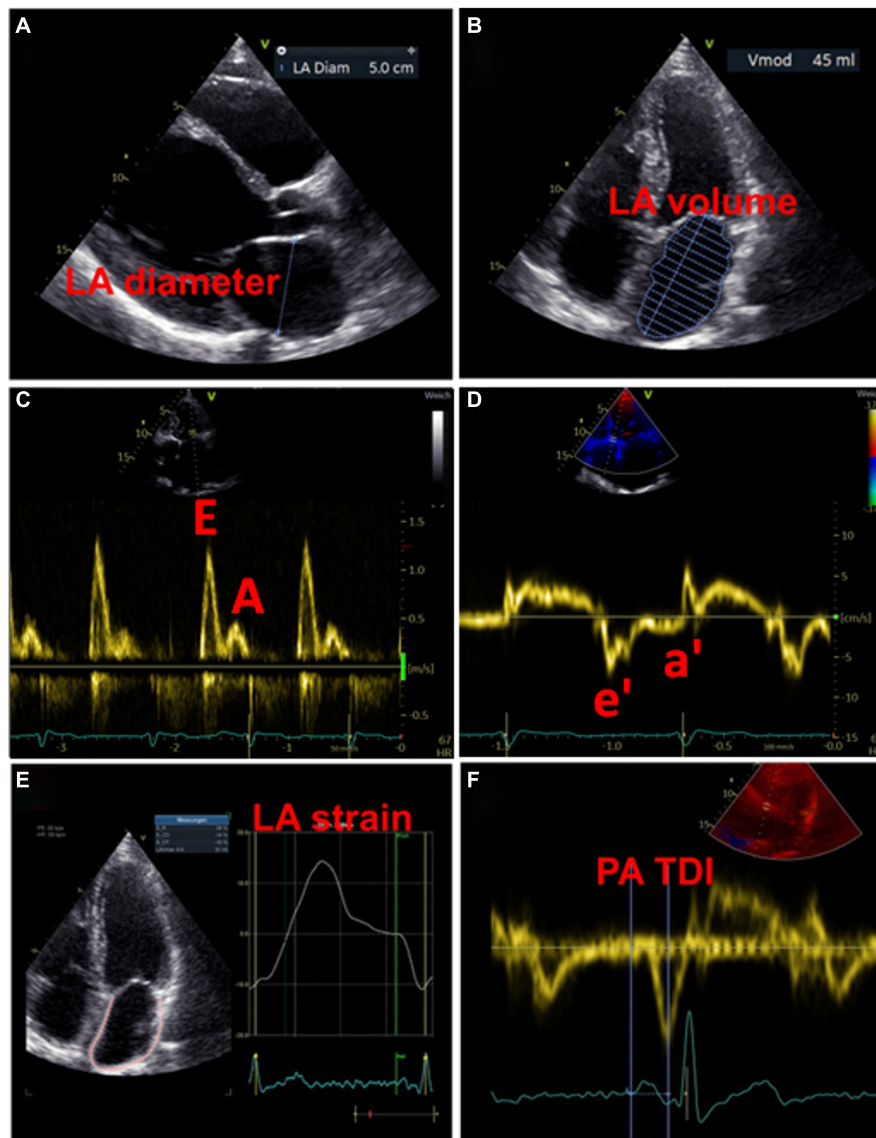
Examples of echocardiographic measurements for the detection of left atrial cardiomyopathy. (A) Measurement of diameter in left atrial diastole. (B) Measurement of left atrial volume in left atrial diastole. (C) Transmittal inflow profile in left ventricular diastole: the first wave represents the E wave (passive inflow of blood into the left ventricle), the second wave represents the A wave (active contraction of the left atrium). (D) Tissue Doppler imaging of the movements of the left ventricular myocardium, in combination with the measurements from (C) the function of the atrium and the left ventricular end-diastolic pressure can be estimated. (E) Strain analysis of the left atrium. (F) Measurement of the PA-TDI interval from the beginning of the P-wave (as the onset of electrical activity of the atrium) to the peak of the a'-wave (mechanical response of atrial contraction).
